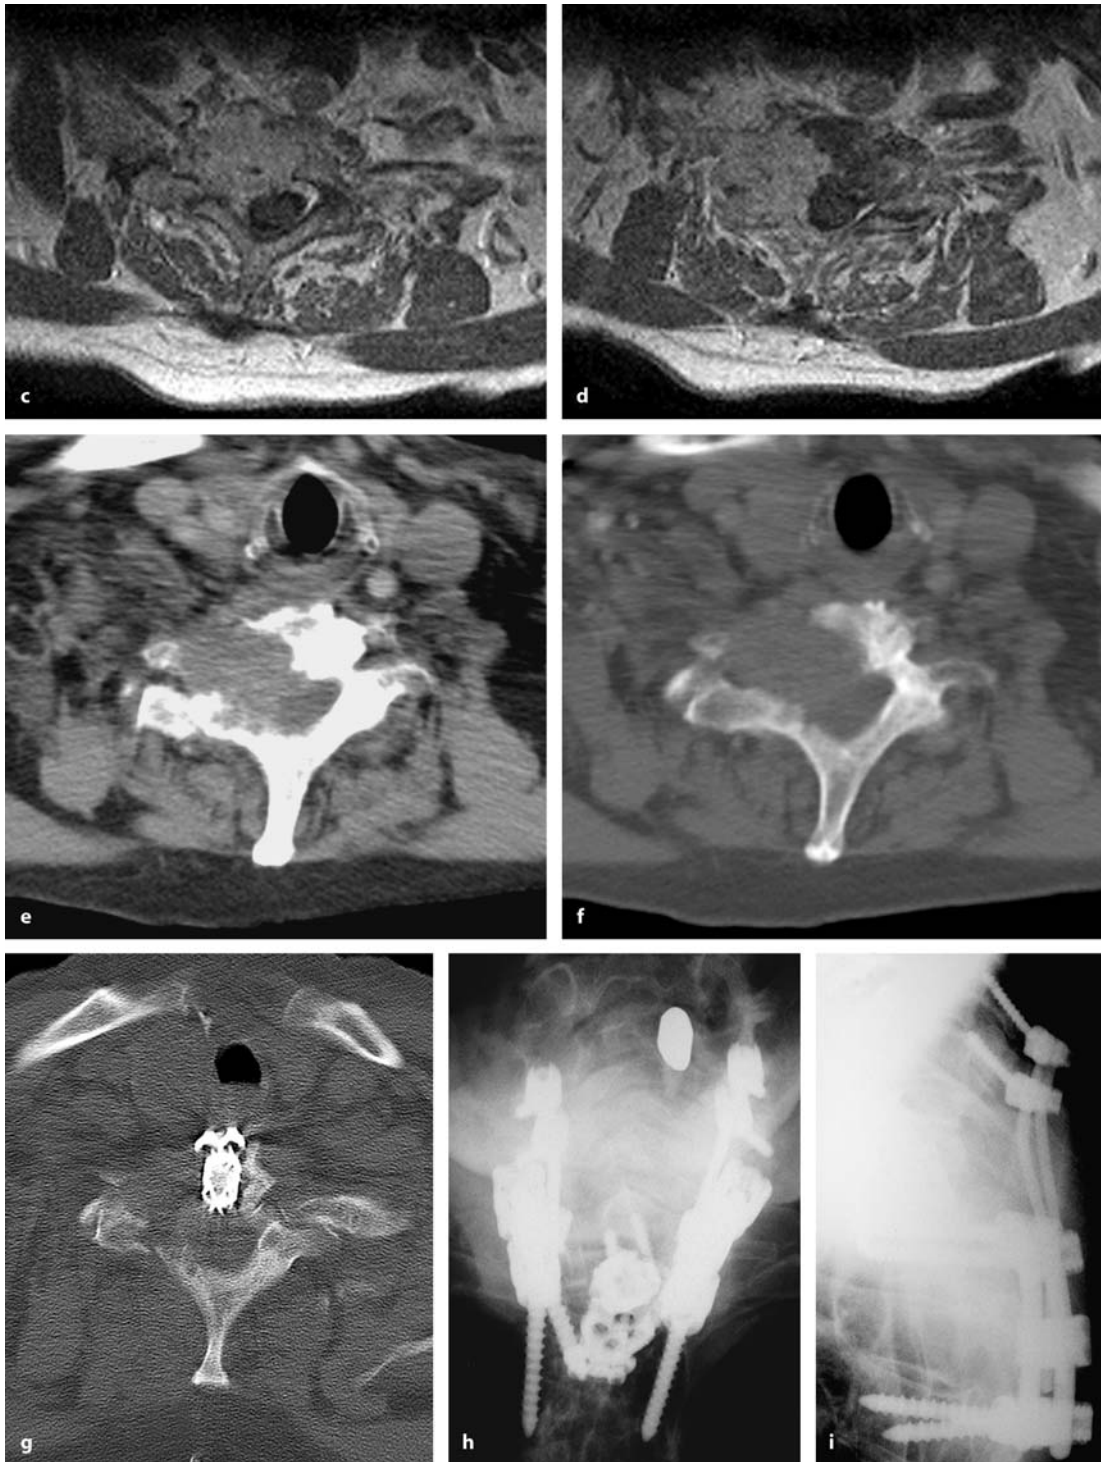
The sagittal T2- (c) and T1-weighted (d) MRI scans demonstrate compression of the dura anteriorly. e An axial T1-weighted scan showing an intraspinal soft-tissue component almost encircling the dura. f The bone-window CT scan
